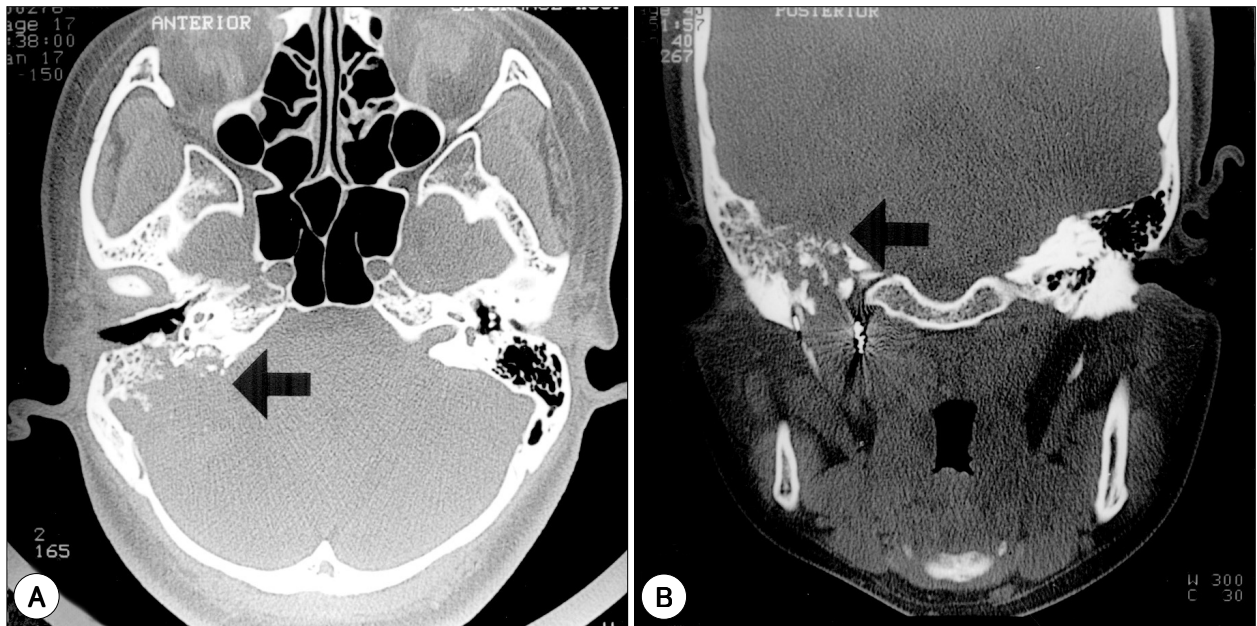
Preoperative temporal bone CT scan. A : Axial CT scan shows a right temporal bone defect surrounded by lytic bone margins. The operculum of vestibular aqueduct is a presumable center of this destructive lesion. B : Coronal CT scan. Intratympanic bone spicules are visible.
